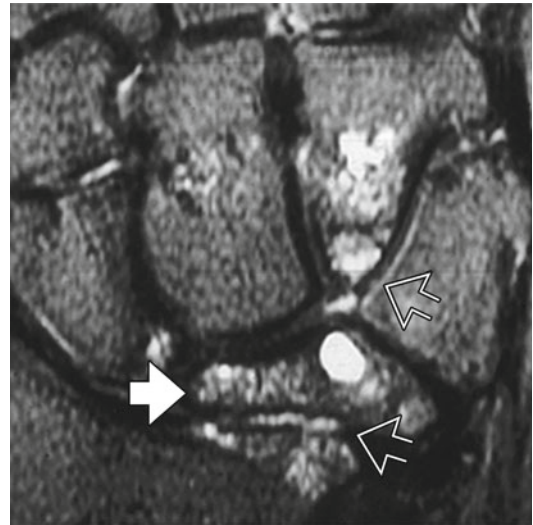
Stage IV Kienböck's disease. Coronal T2-weighted MRI image revealing lunate collapse (*solid arrow*), with secondary degenerative arthrosis in the radiocarpal and midcarpal joint compartments (*open arrow*)
